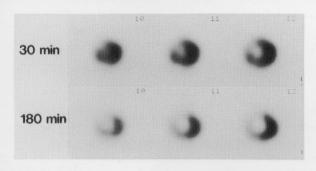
Early and delayed Tc-99m-tetrofosmin myocardial SPECT images of a patient with anterior acute myocardial infarction with successful direct PTCA. Mildly decreased uptake of the tracer in the anterior and septal segments is observed on the early images (upper). Decreased uptake regions are expand, and more severely decreased uptake is observed on delayed images (reverse redistribution).
